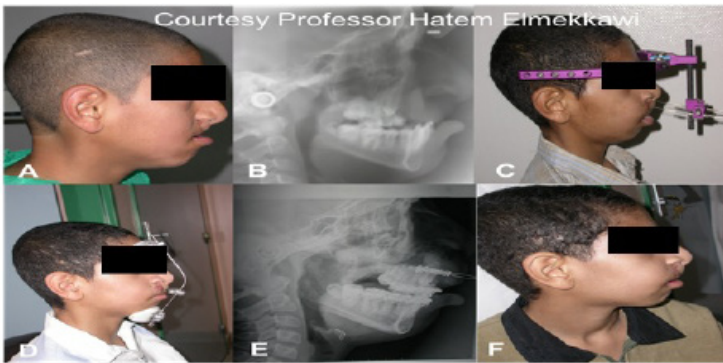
Maxillary advancement following cleft repair. A clinical picture shows maxillary retrognathia. B. Radiograph shows severe maxillary retrognathia. C. RED device in place. D. Post-distraction retention phase using face mask. E. Radiograph shows maxillary advancement with the Device in place. E. post-operative picture .
